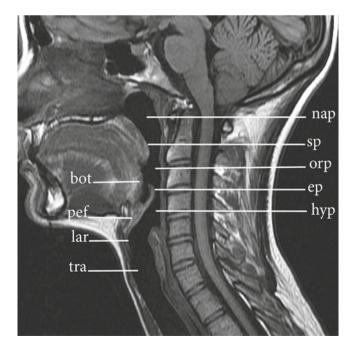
Normal anatomical sag MRI
